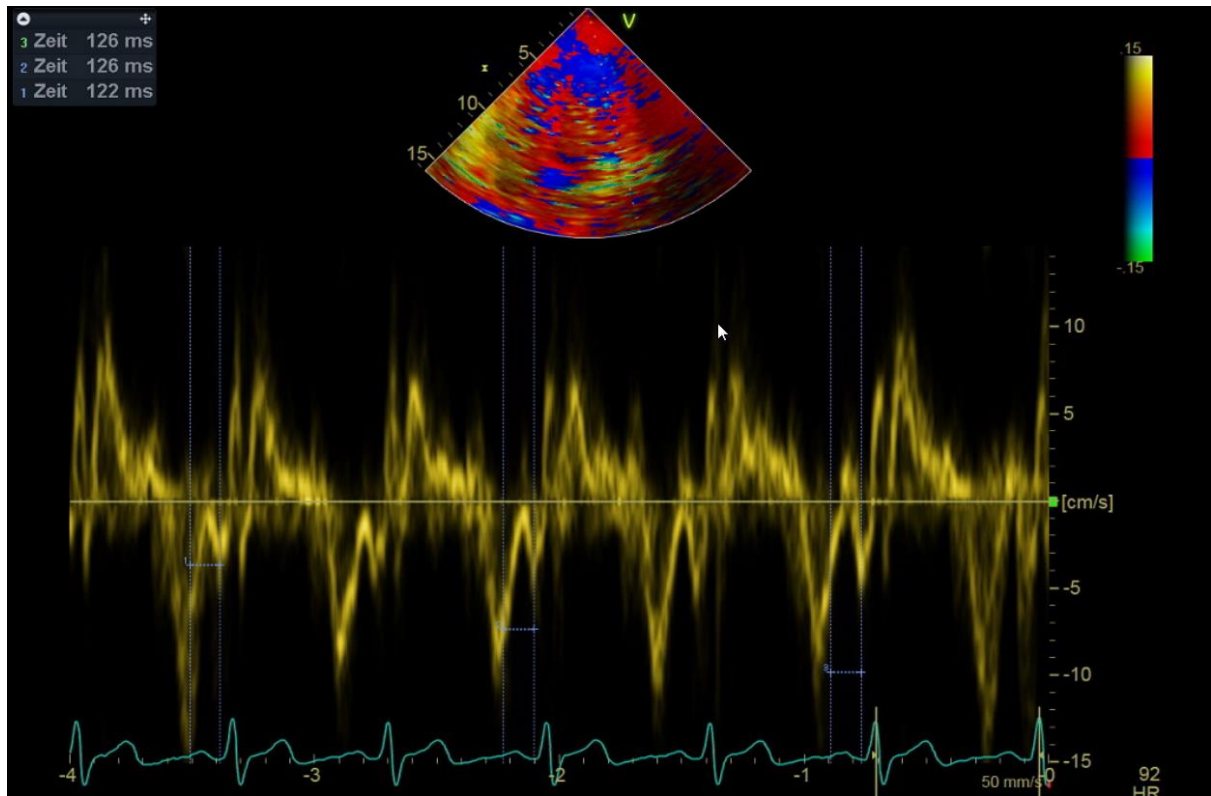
Transthoracic echocardiogram showing the PA-TDI interval. This figure is an echocardiographic example the measurement of the total atrial conduction. The total atrial conduction time is represented by the PA-TDI interval. The PA-TDI interval is the distance between peak A of the tissue doppler Image of the lateral mitral valve annulus and the beginning of the p-wave in lead II.
